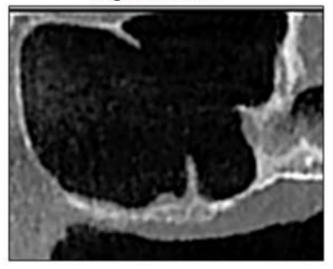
b: Multiple Septa detected in right MS CBCT image
